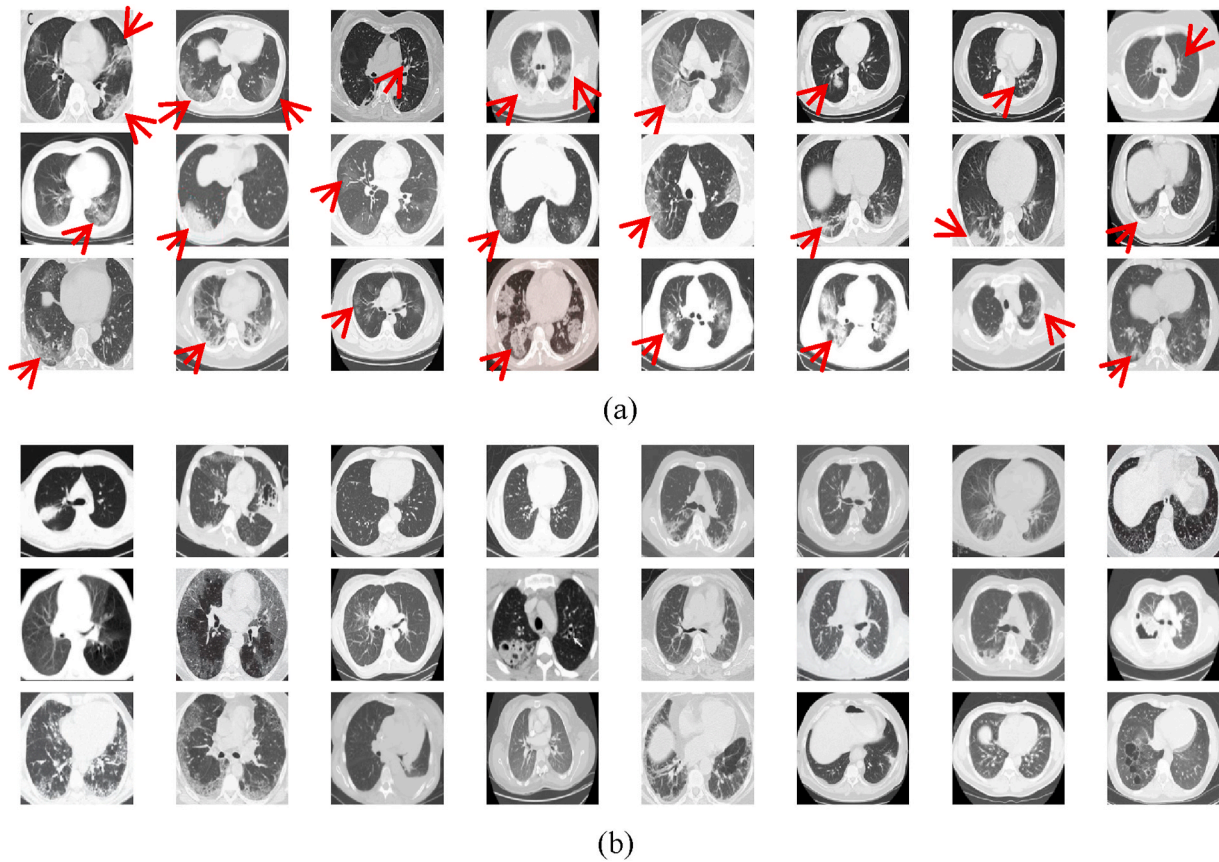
The COVID-CT dataset. (a) COVID-19 positive image; (b) COVID-19 negative image.
